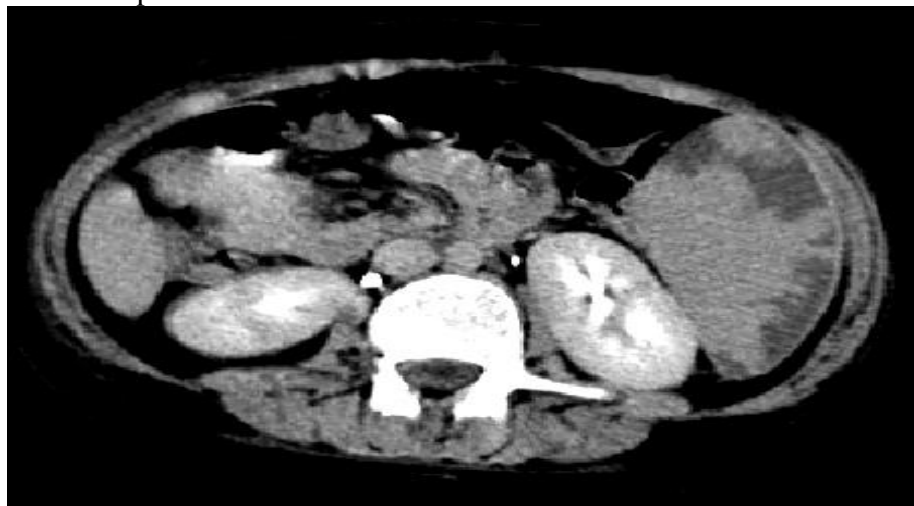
CT scan image of this patient showing splenomegaly with multiple splenic infarcts.
